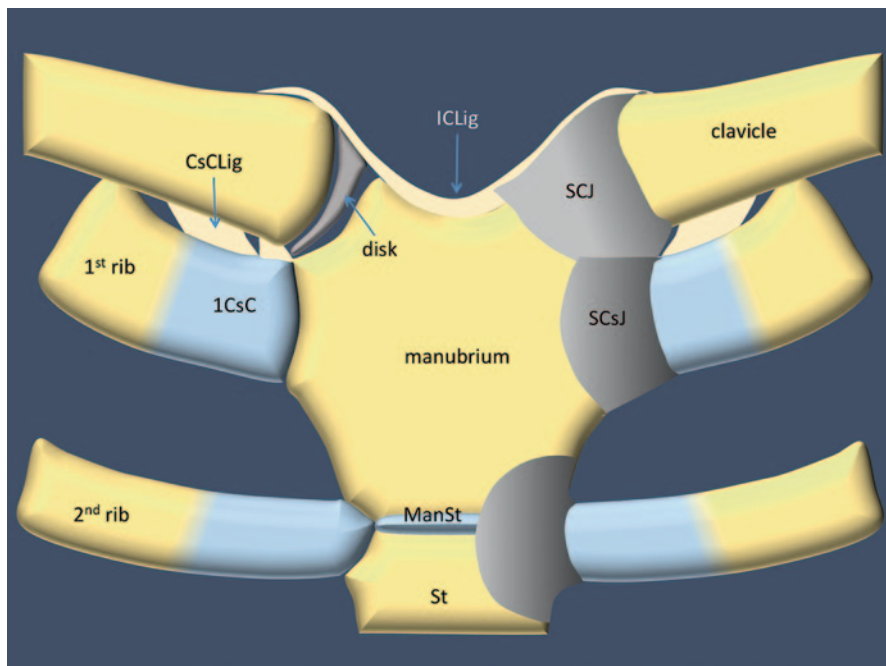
Anatomy of the parasternal joints. *BS* body of sternum, *ManSt* manubriosternal symphysis, *SCJ* sternoclavicular joint, *ICLig* interclavicular ligament, *SCsJ* sternocostal joint, *CsCLig* costoclavicular ligament, *1CsC* first costal cartilage
